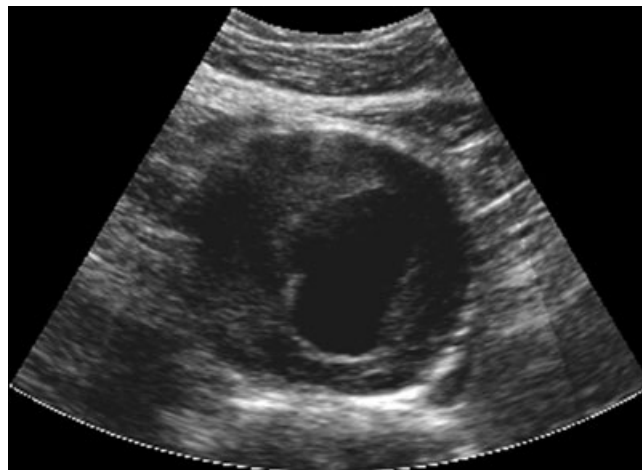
Ultrasound image of abdominal aortic aneurysm. Notice the presence of large thrombus inside the aneurysm sac.
